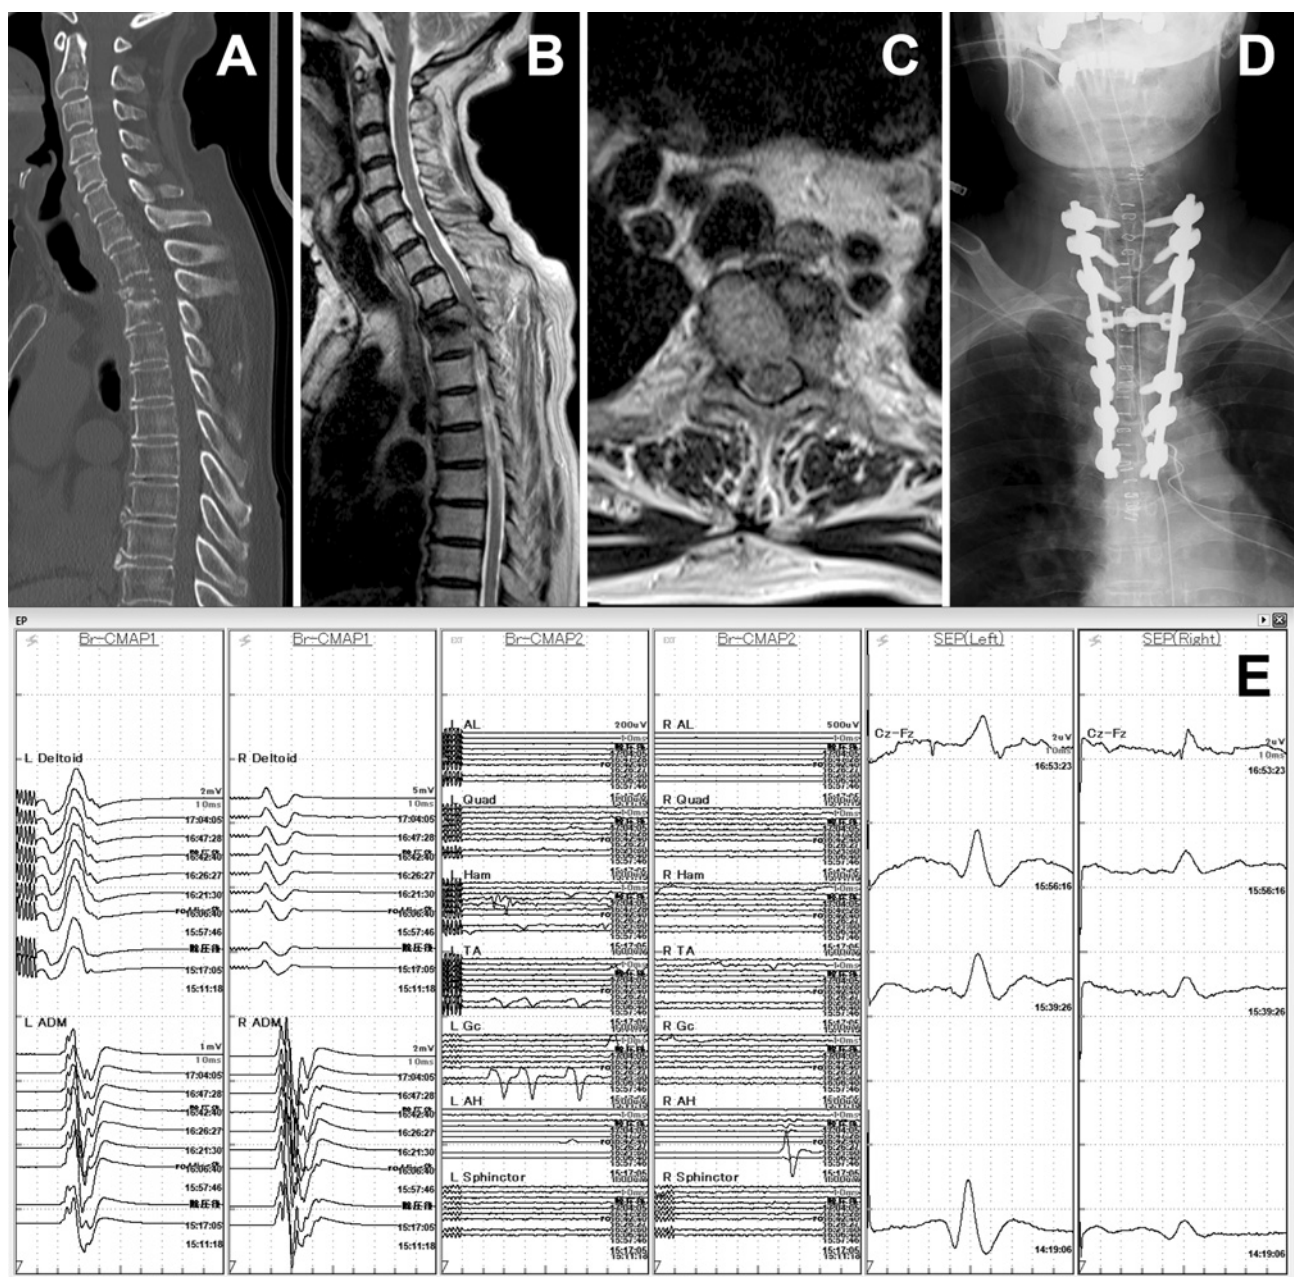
Unrecordable Tc-MEP cases. A woman in her 60s with breast cancer thoracic metastasis (A, CT sagittal image; B, MRI T2-weighted sagittal image; C, MRI T2-weighted trans image) and muscle weakness with an MMT score of 4 for both lower extremities underwent posterior decompression and fusion (D). Tc-MEP recording was impossible in any lower extremity muscle (E). However, there was no deterioration in the muscle strength of both lower extremities postoperatively, and the muscle strength improved afterward. CT, computed tomography; MRI, magnetic resonance imaging; MMT, manual muscle test; Tc-MEP, transcranial motor evoked potential; ADM, abductor digiti minimi; AL, adductor longus; Quad, quadriceps; Ham, hamstrings; TA, tibialis anterior; Gc, gastrocnemius; AH, abductor hallucis
